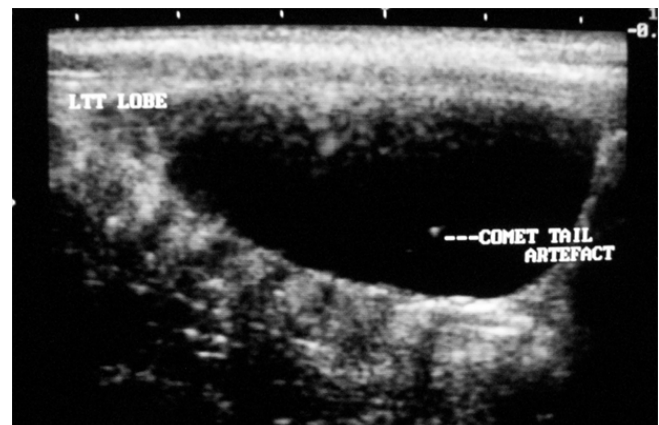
Ultrasonography of goiter with cystic changes shows comet tail artifact
